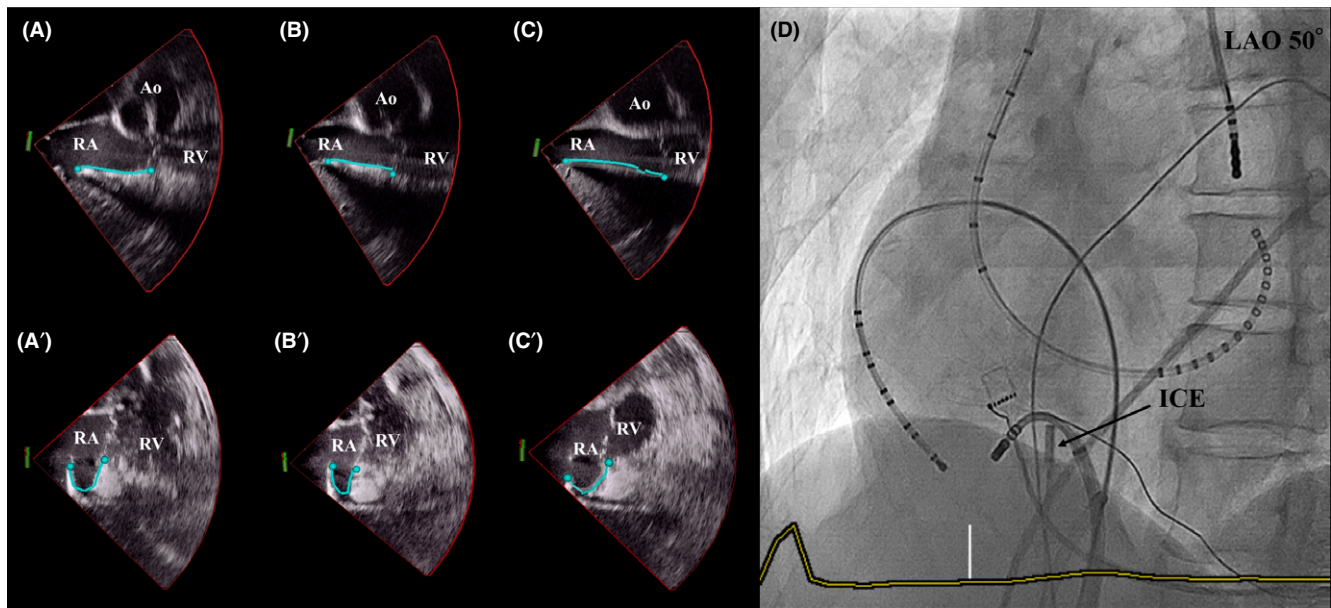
Intracardiac echocardiography (ICE) viewed from the RA. The light blue tracings demarcate the CTI. Upper panels: a case without a pouch. A, B, C: septal, medial, and lateral aspects of the CTI, respectively. The length of the lateral, medial, and septal CTI was 51 mm, 44 mm, and 37 mm, respectively. The lateral CTI was clearly the longest. Lower panels: a case with a deep pouch. A', B', C': septal, medial, and lateral aspects of the CTI as above. The pouch depth was 12 mm in this case along the lateral CTI. The pouch depth of the lateral site was significantly shallower compared to the others. D: Cine fluoroscopic image from LAO50°. ICE catheter positioned at the low right atrium. CTI, cavotricuspid isthmus; RA, right atrium; RV, right ventricle; Ao, aorta; ICE, Intracardiac echocardiography; LAO, left anterior oblique
